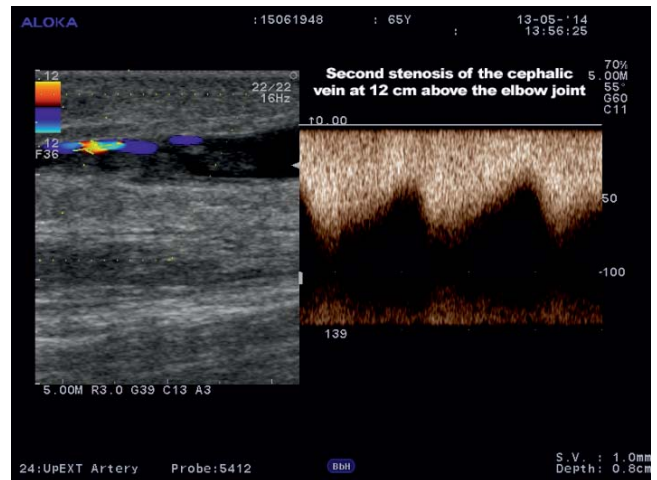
Color Doppler ultrasound of the cephalic vein. A second stenosis was identified at 12 cm above elbow joint.
